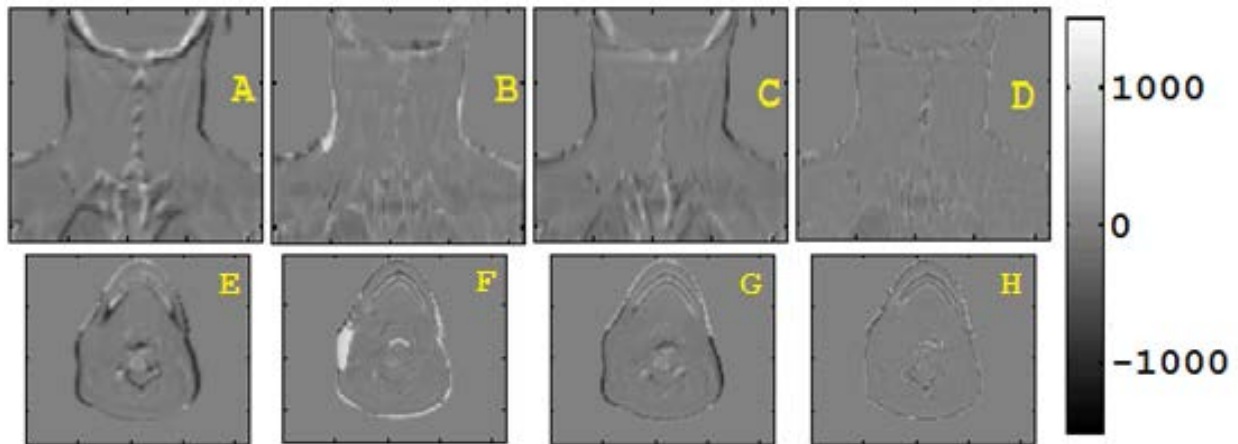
Mid sagittal slice (top row) and mid axial slice (bottom row) of the CBCT subtracted from the, CT (A, E), Demons deformed CT (B, F), intensity corrected Demons deformed CT (C, G), LDIR deformed CT (D, H).
